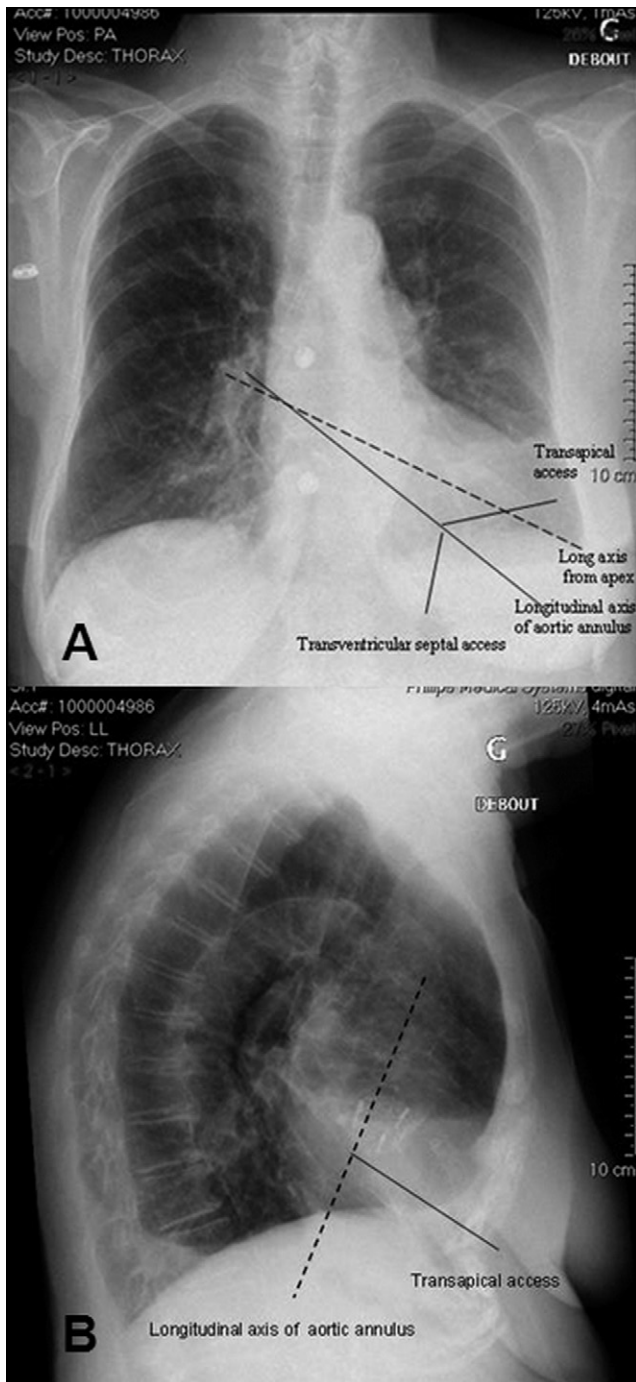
Although an anterior-posterior chest view suggest an almost perfect alignment between the apical access and the aortic annulus, this is not necessarily true. As a matter of fact, the left lateral radiograph after trans-apical aortic valved stent implantation shows that the direction of trans-apical procedure is not parallel to the axis of aortic annulus and there is an obvious angle between them.
